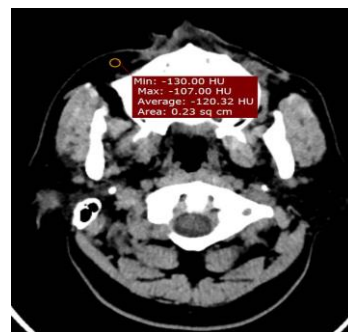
Axial non contrast CT image demonstrating fat density lesion in right premaxillary region
